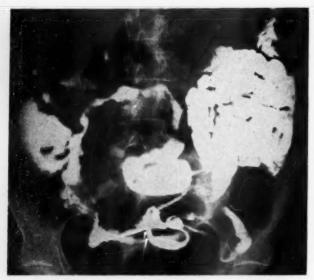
Case i. X-ray film of small bowel taken on November 29, 1956, showing abnormal ribbon-like pattern with pooling of barium.
